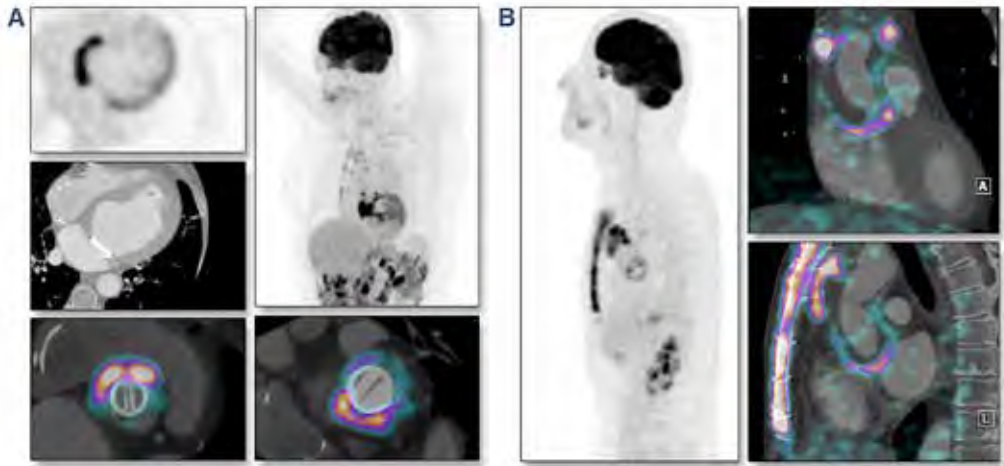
Infection versus inflammation. (A) Images show a patient with both aortic and mitral mechanical PHV with intense ^{18}F -FDG uptake in the entire basal septum extending to both PHV. Minor uptake in the lateral wall is physiological based on incomplete suppression. Antibiotics did not change the clinical presentation, and re-evaluation of biopsy samples led to the diagnosis of sterile granuloma, possibly sarcoidosis. Symptoms diminished under corticosteroid therapy. (B) Images show a patient with suspicion of endocarditis of biological PHV and Bentall prosthesis. There is intense accumulation of ^{18}F -FDG surrounding the implant (aortic valve and ascending aorta), indicative of widespread inflammation. During implantation, surgical adhesive had been applied to ensure hemostasis. The accumulation of ^{18}F -FDG is most likely based on sterile inflammation due to the surgical adhesive and not due to infective endocarditis. This was confirmed during unrelated thoracic surgery. These images highlight the inability to reliably differentiate between infection and sterile inflammatory processes.
